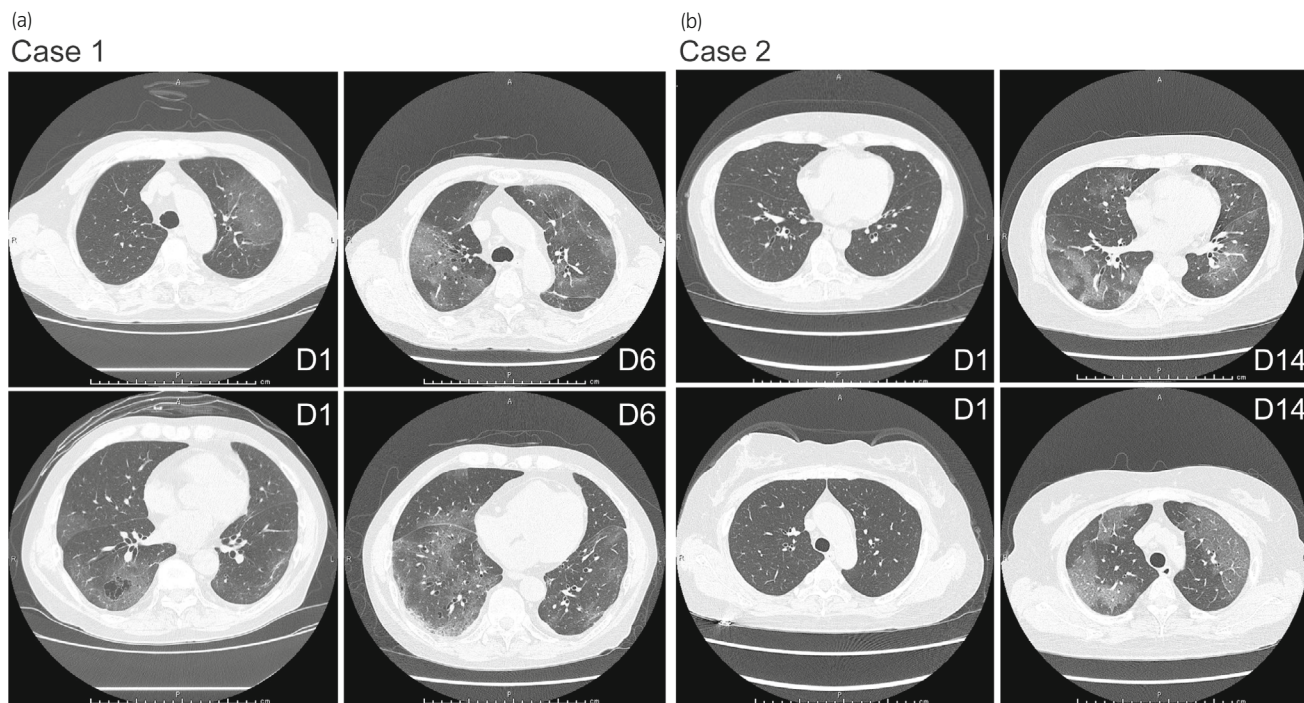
Chest CT images. (a) In case 1, CT obtained on day 1 after admission shows left upper lobe and peripheral GGOs. Follow-up chest CT images obtained on day 6 after admission show worsening of pneumonia in the lower lung fields. (b) In case 2, CT images obtained on day 1 after admission show almost no findings of pneumonia. Follow-up chest CT images obtained on day 14 after admission show worsening of pneumonia in the lower lung fields.
